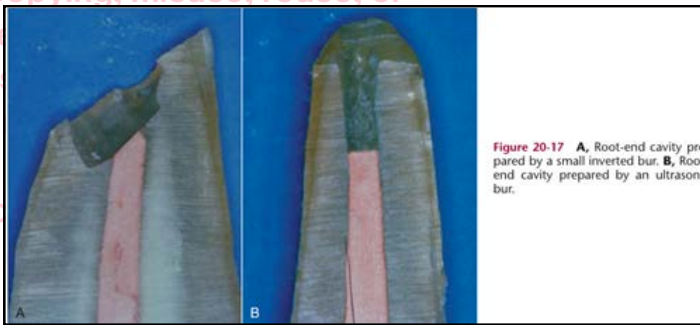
A, Root-end cavity prepared by a small inverted bur. B, Root-end cavity prepared by an ultrasonic bur.
